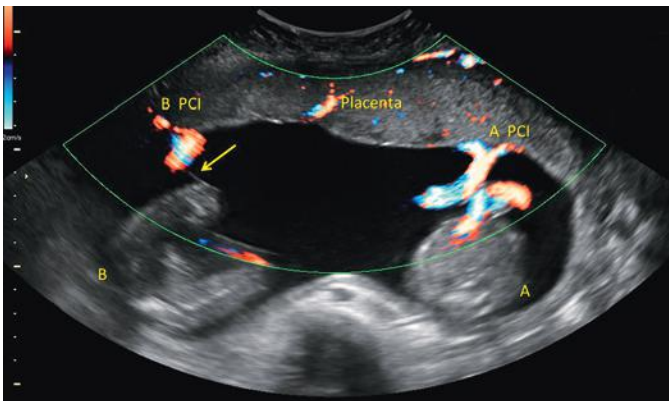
Color flow Doppler ultrasound imaging is used to identify each placental cord insertion (PCI) of the monozygotic diamniotic twin pair (A and B). The thin inter-twin membrane is in close proximity to twin B (*arrow*).
